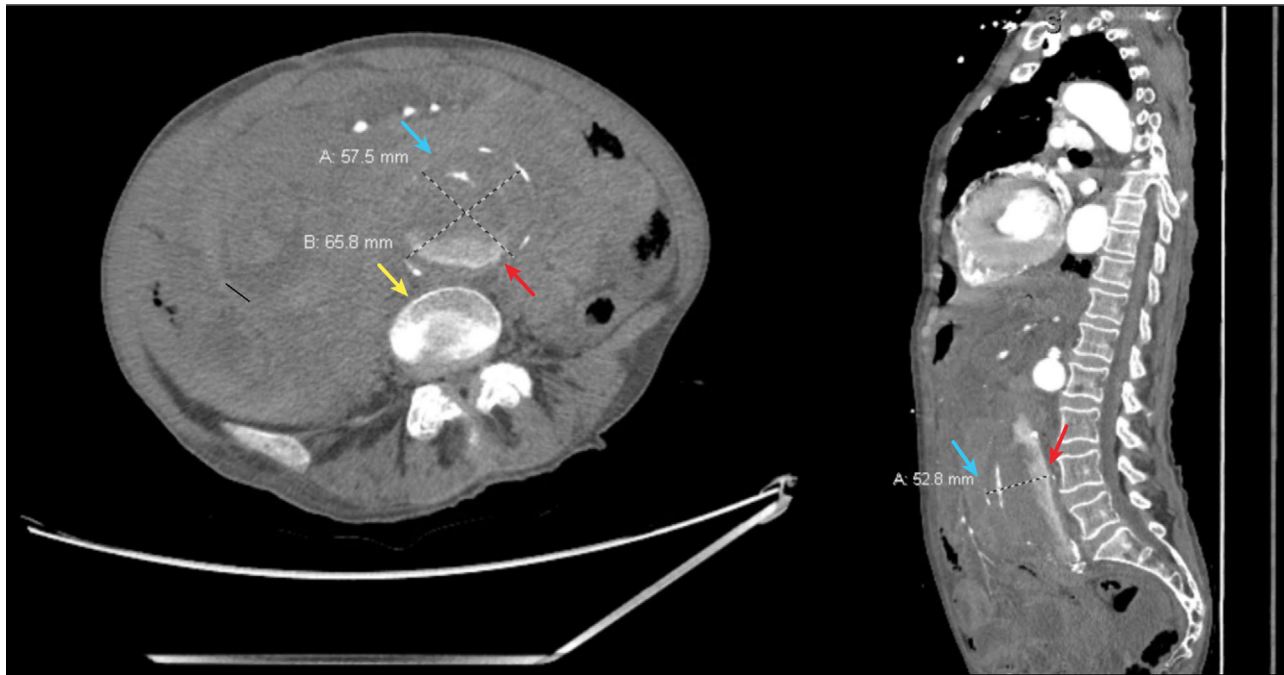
Computed tomography aortogram confirmed an aortic aneurysm and a large-volume hemoperitoneum consistent with an aortic aneurysm rupture at the infrarenal aorta extending to the bilateral proximal common iliac arteries (blue arrows, anterior wall of the abdominal aorta; red arrows, posterior wall of the abdominal aorta; yellow arrow, anterior aspect of the spine/vertebral body)
